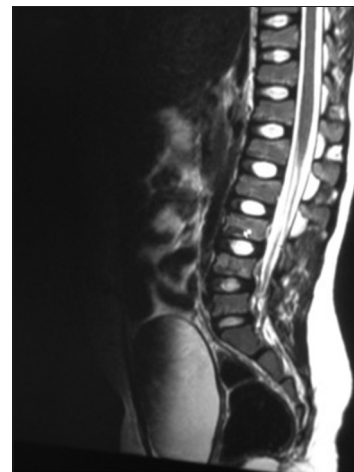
Magnetic resonance imaging of the spine of the child. The cursor shows features of anterior wedge configuration of dorsal vertebral bodies in L3–L5 vertebrae
